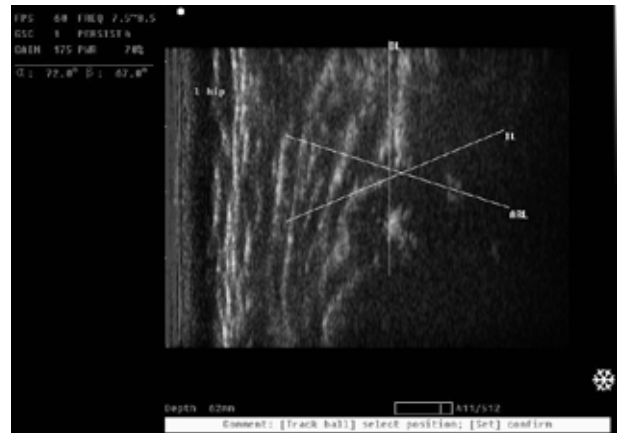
Sonographic image of infant with α -angle = 72° and β -angle = 67°, type Ib in Graf classification
